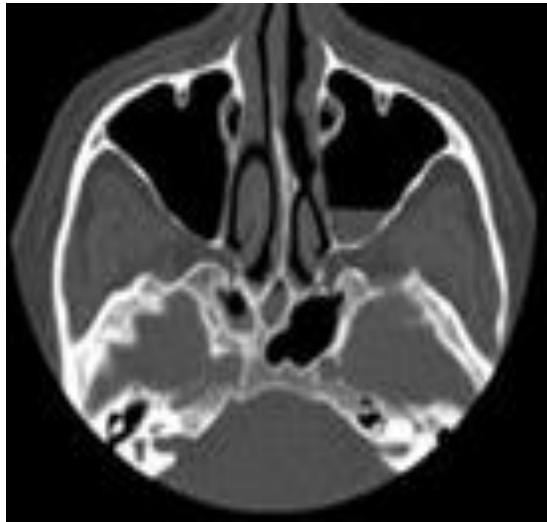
CT features of acute bacterial sinusitis. Axial CT image showing an air–fluid level in left maxillary sinus and mild mucosal thickening in the right maxillary sinus consistent with acute bacterial inflammation. (CT Image provided by Dr. A. Gharibyan)
